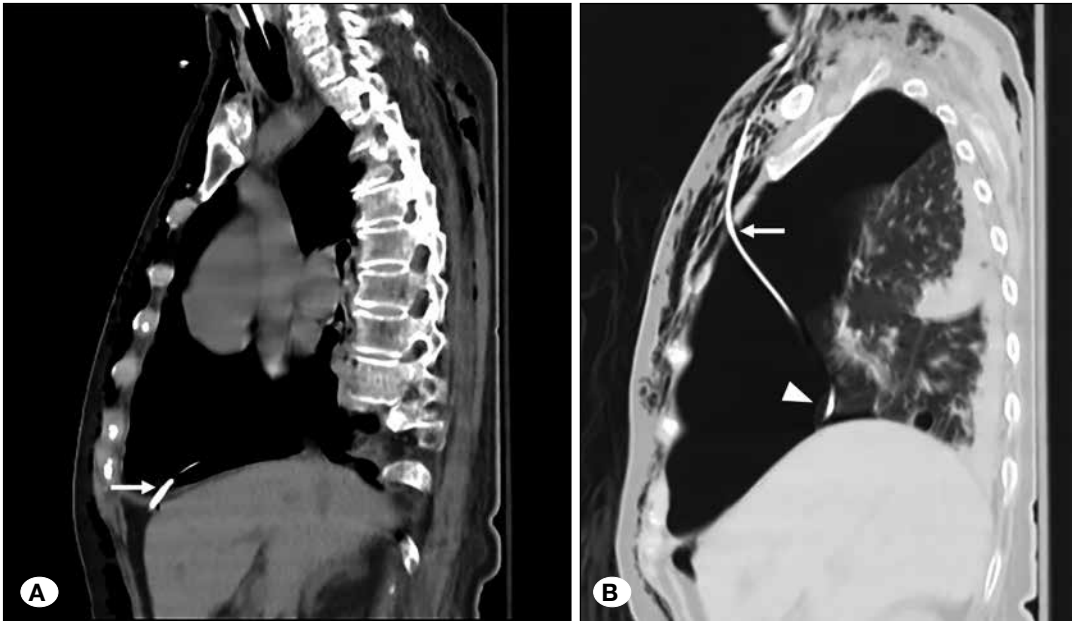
A) A chest CT scan revealed that the shunt tube penetrated the diaphragm (arrow) and entered the pleural space. B) The shunt tube penetrated the lung parenchyma (arrowhead) and exited the pleural space via the third intercostal space (arrow).
